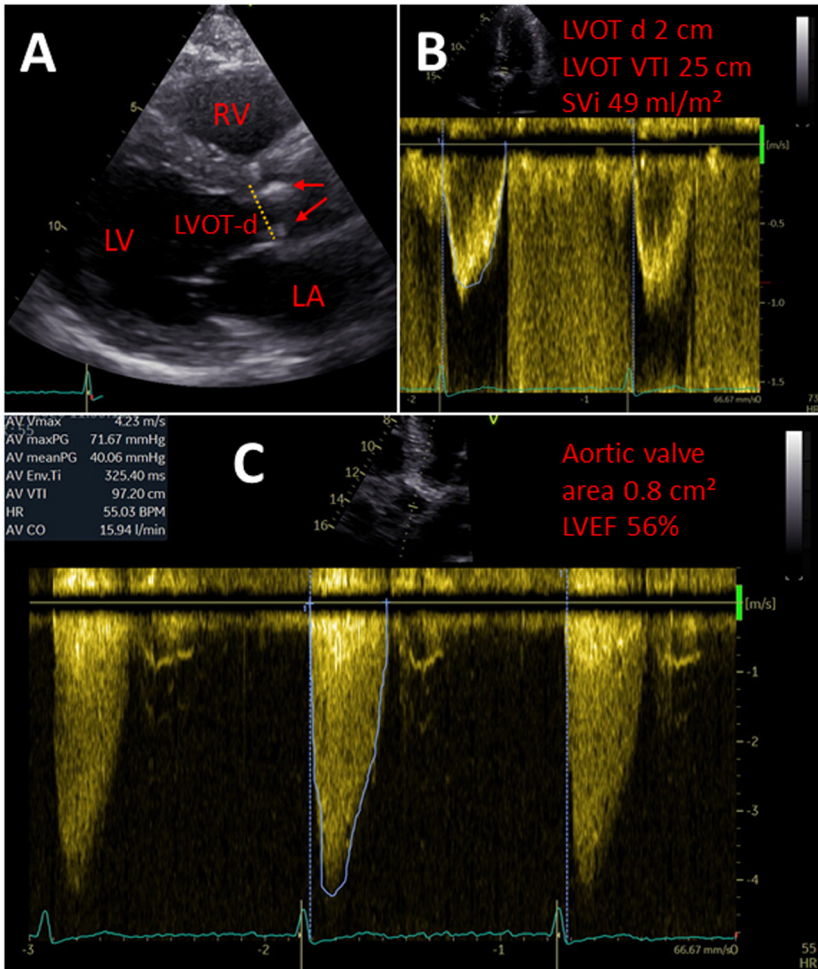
Echocardiographic images of a 90-year-old male patient with severe aortic stenosis (AS) who presented with a systolic murmur grade 3/6 on aortic valve location (Second right and Third left intercostal space near sternum) and preserved second heart sound. On parasternal long-axis view (A), aortic valve is not so calcified (red arrows), and aortic flow is normal (stroke volume index [49 ml/m²]) (B). However, peak aortic jet velocity is 4.2 m/s (C), consistent with severe AS. Left ventricular ejection fraction (LVEF) was 56%. Color version of figure is available online.
